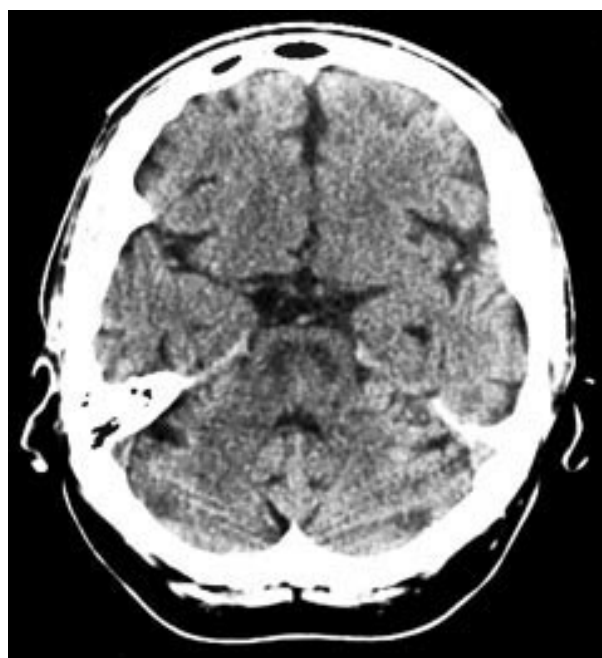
Computed tomographic (CT) scan demonstrating the typical “bat wing” appearance of central pontine myelinolysis in a patient recovering from depressed consciousness with accompanying electrolyte derangement.
